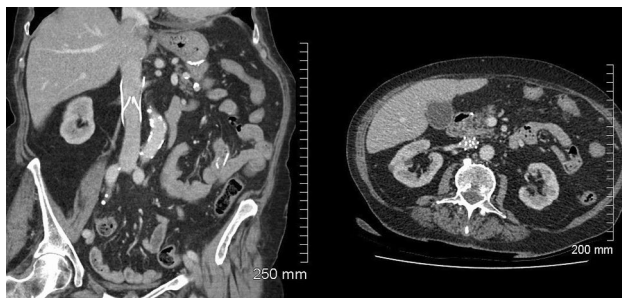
Coronal (left) and axial (right) CT images in the early post-operative period demonstrate the filter in its expected filtering configuration with the arms of the filter held together by a bioabsorbable filament
